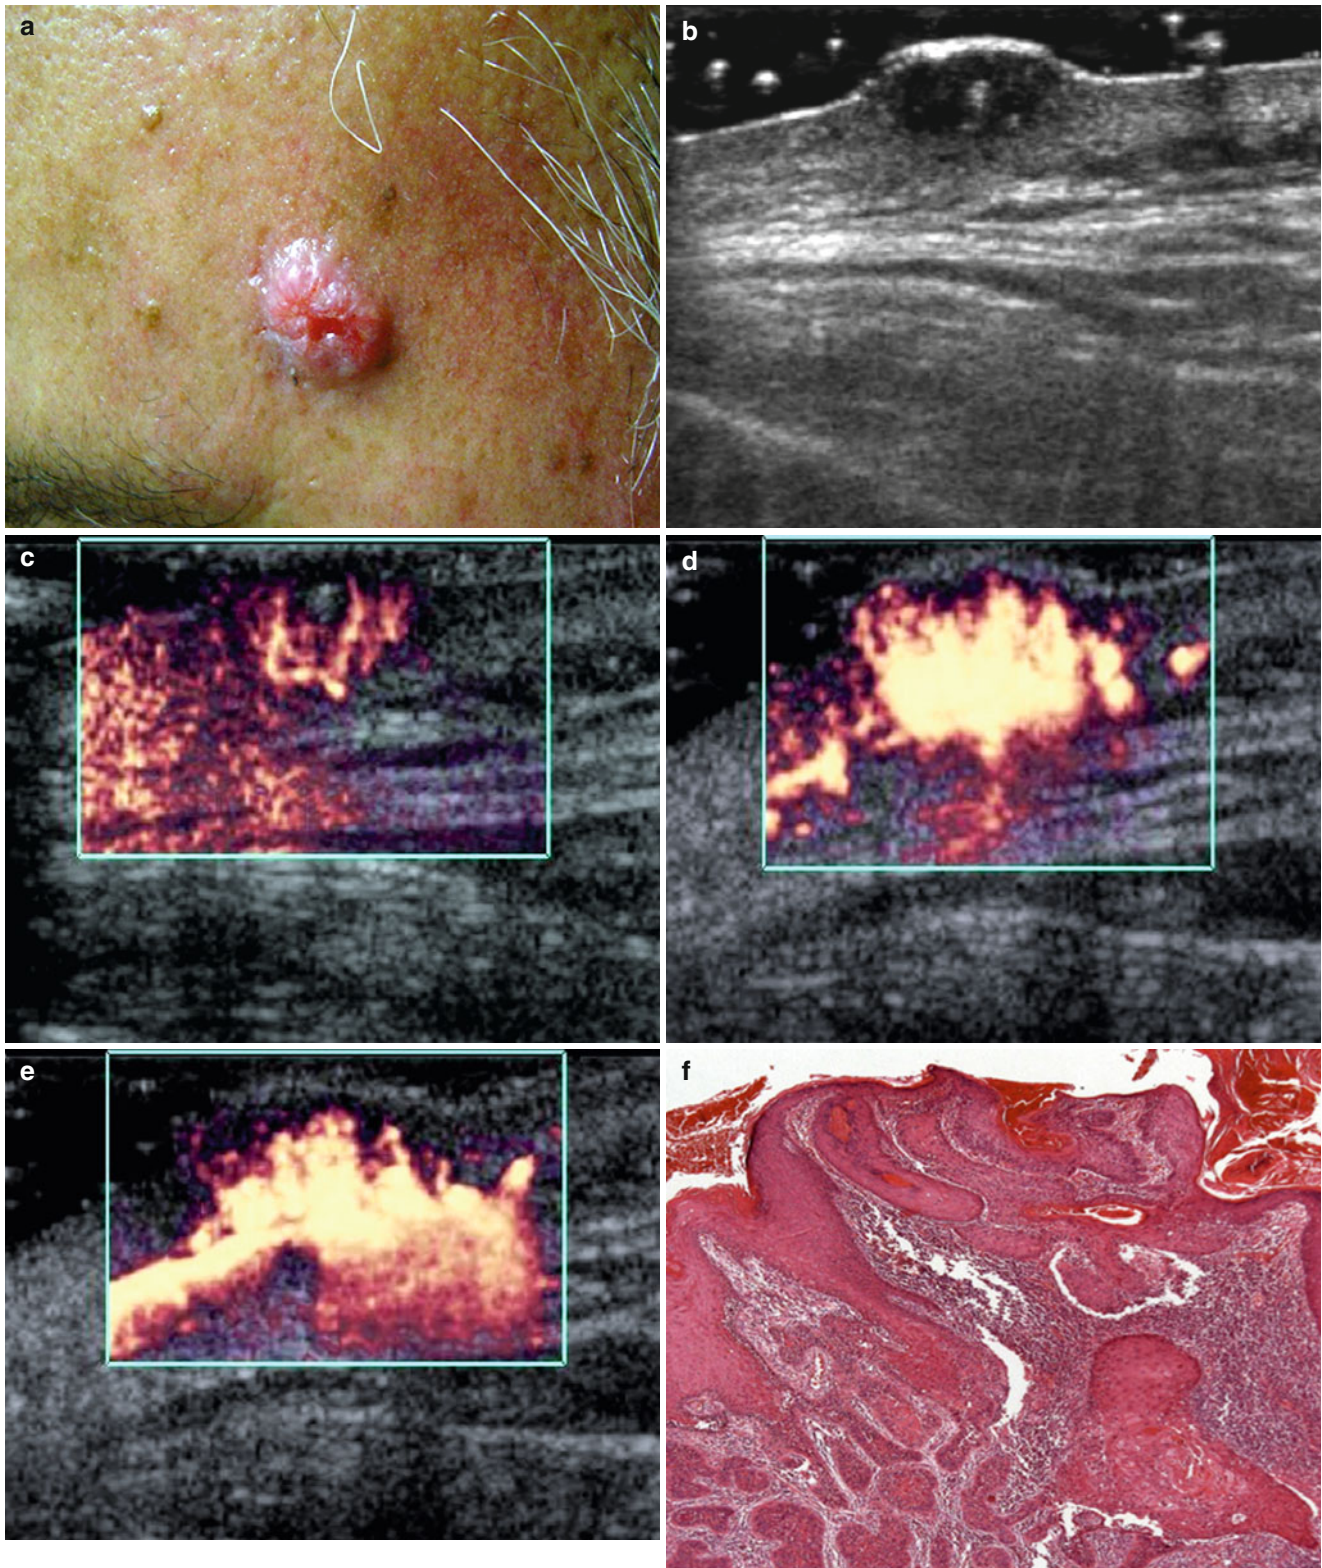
(a) Squamous cell carcinoma in temporal region. (b) Grey scale ultrasound image—Lesion occupying dermis. (c) Power Doppler ultrasound image before contrast—some vessels seen in central region.
